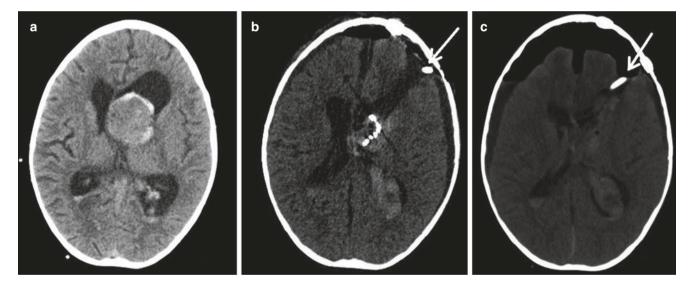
In a 7-year-old girl, surgical removal of a tumor of the left lateral ventricle was complicated by retention of a cottonoid in the wound. The lesion, which predominantly occupied the anterior horn (a), was resected via a left-side transcortical approach. Control computed tomography (CT) in 12 h after the surgery (b) revealed a radiopaque
